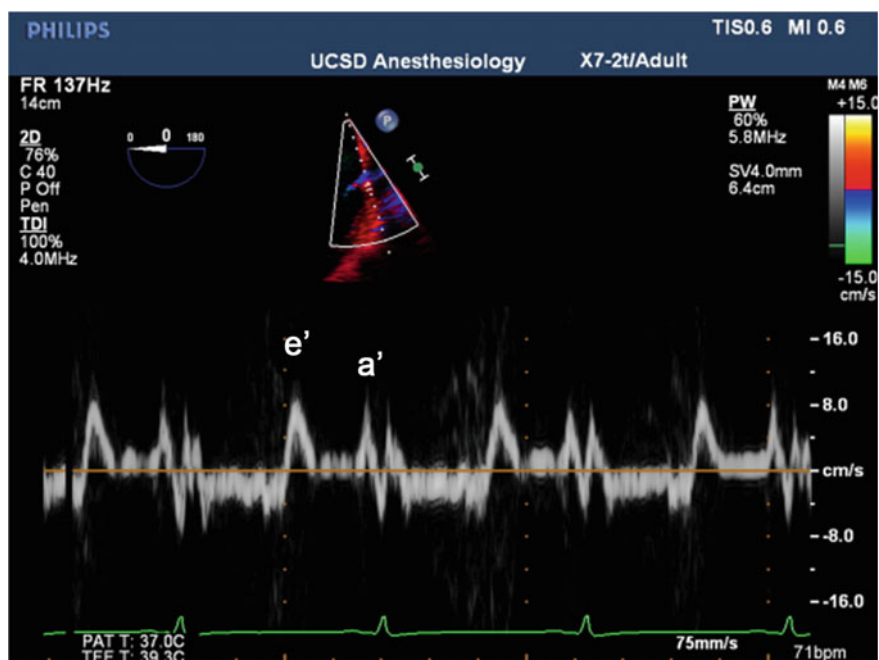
Tissue doppler interrogation measuring the upward velocity of the atrial myocardium and mitral annulus during diastole. The e'-wave corresponds to ascension of the atrial myocardium and mitral annulus during IVRT. The a'-wave corresponds to movement of the myocardium just before atrial contraction
